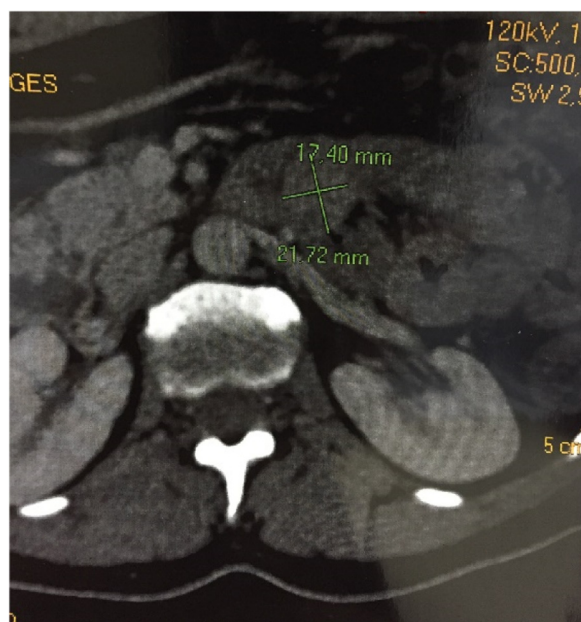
Computed tomography of the abdomen showing nodular lesion in the first jejunal portion.
